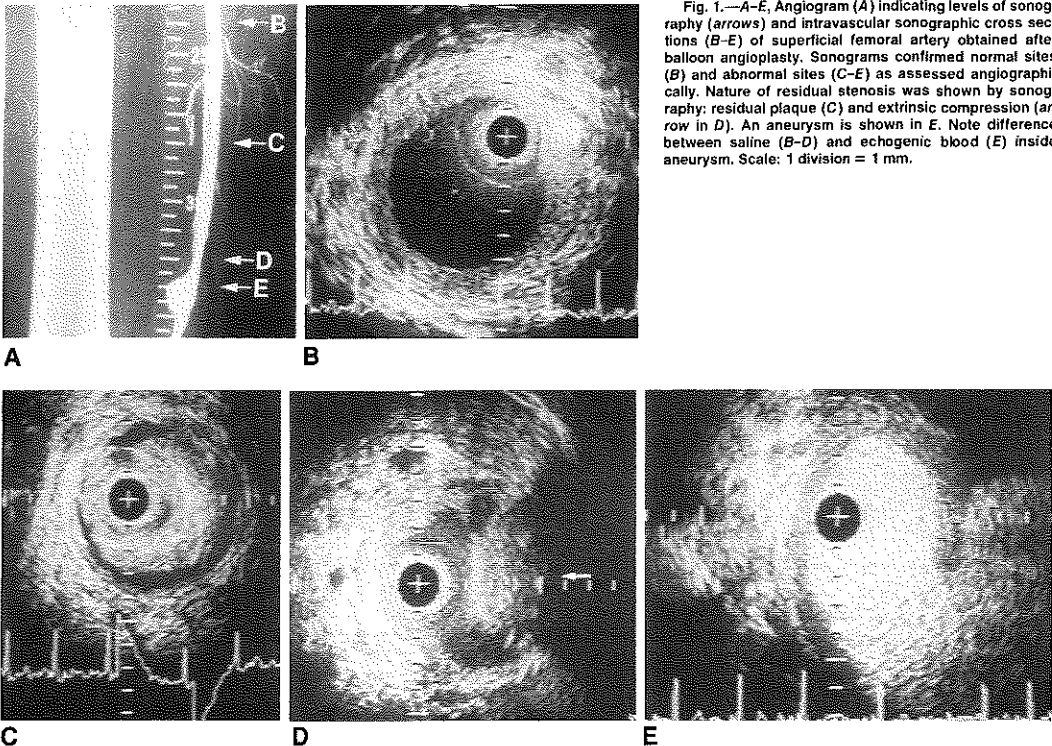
A–E, Angiogram (A) indicating levels of sonography (arrows) and intravascular sonographic cross sections (B–E) of superficial femoral artery obtained after balloon angioplasty. Sonograms confirmed normal sites (B) and abnormal sites (C–E) as assessed angiographically. Nature of residual stenosis was shown by sonography: residual plaque (C) and extrinsic compression (arrow in D). An aneurysm is shown in E. Note difference between saline (B–D) and echogenic blood (E) inside aneurysm. Scale: 1 division = 1 mm.
